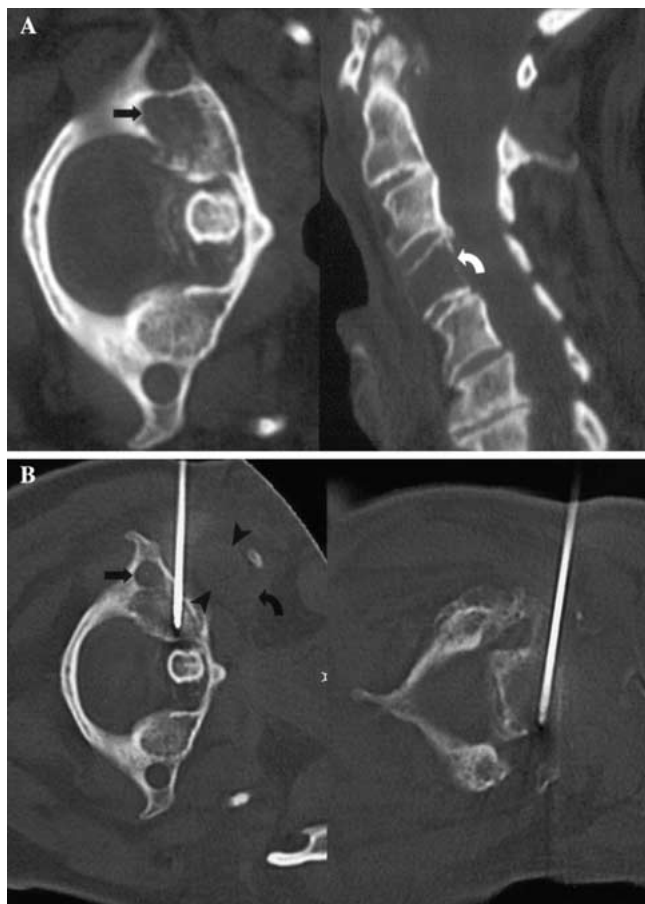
A. Axial computed tomography showing an osteolytic lesion of the right lateral atlas mass (arrow) and another osteolysis in a sagittal reconstruction of C4 (curved arrow). The right-sided osteolytic lesion of the atlas abuts the vertebral artery. The cortex along the vertebral artery is intact, whereas at the medial cortex, a fracture zone with mild displacement can be delineated. Note the cortical breakthrough of the posterior vertebral surface at the C4 level. B. Lateral access path to the osteolytic lesion in C1 (left) and the entirely destroyed C4 (right) between the internal carotid artery (curved arrow)/internal jugular vein (arrowhead) anteriorly and the vertebral artery (arrow) posteriorly under CT fluoroscopic guidance.
